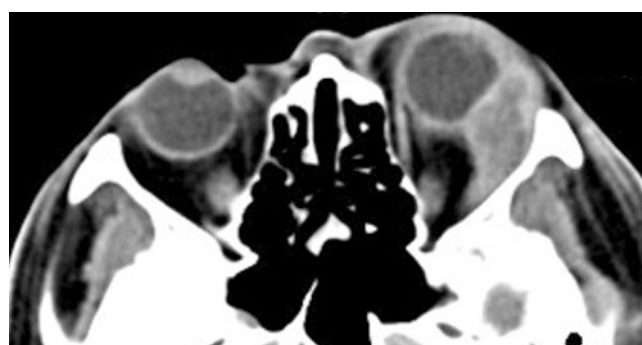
Axial contrast-enhanced CT showing a left lateral rectus mass indenting the globe
